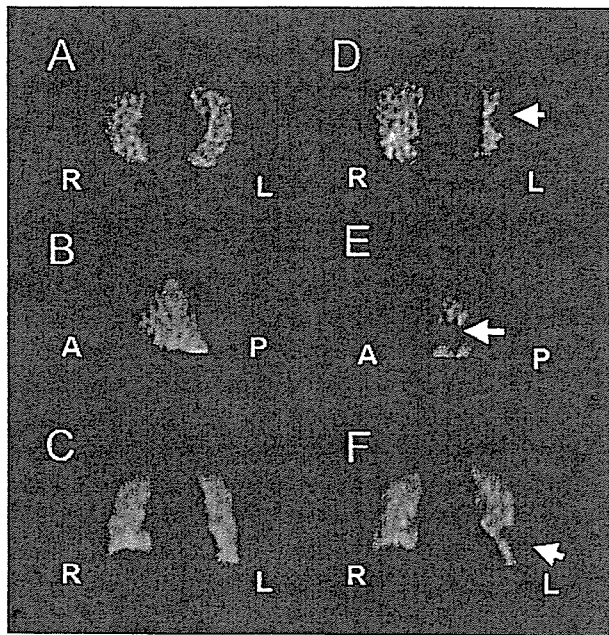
Baseline SPECT (A–C) and postoperative SPECT (D–F) in a patient with postoperative segmental defect. Defects are marked by arrows. SPECT, single-photon emission computed tomography; R, right; L, left; A, anterior; P, posterior
